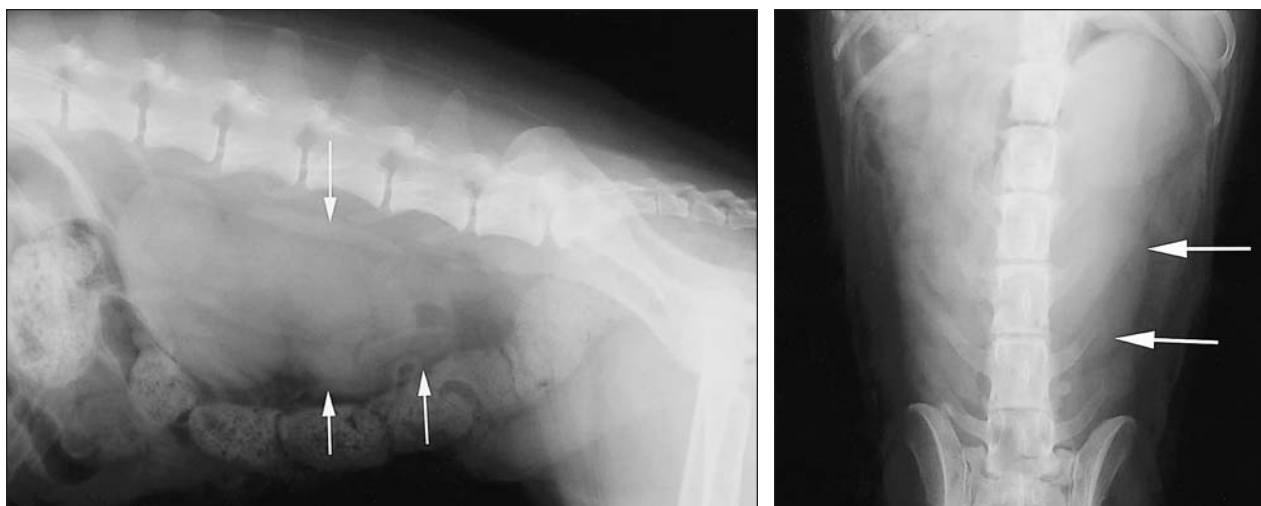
Same radiographic views as in Figure 1. Notice the tortuous soft-tissue opacity in the left caudal region of the abdomen (arrows). The right kidney is not apparent.
